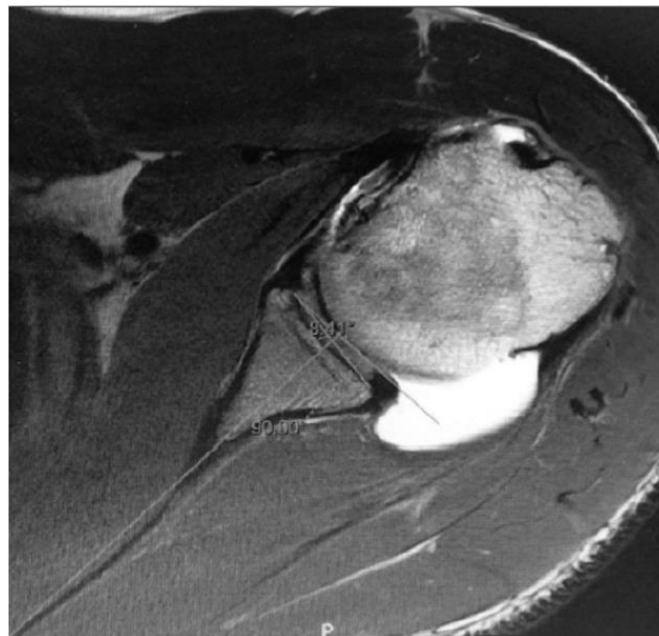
Image showing MRI axial cuts (Proton density, fat saturated) with measurement of the osseous Glenoid version based on the criteria used by Kim et al [17] (Angle between the perpendicular drawn from the plane of scapula and the plane of the osseous portion of Glenoid -8.41 degrees in this shoulder).
